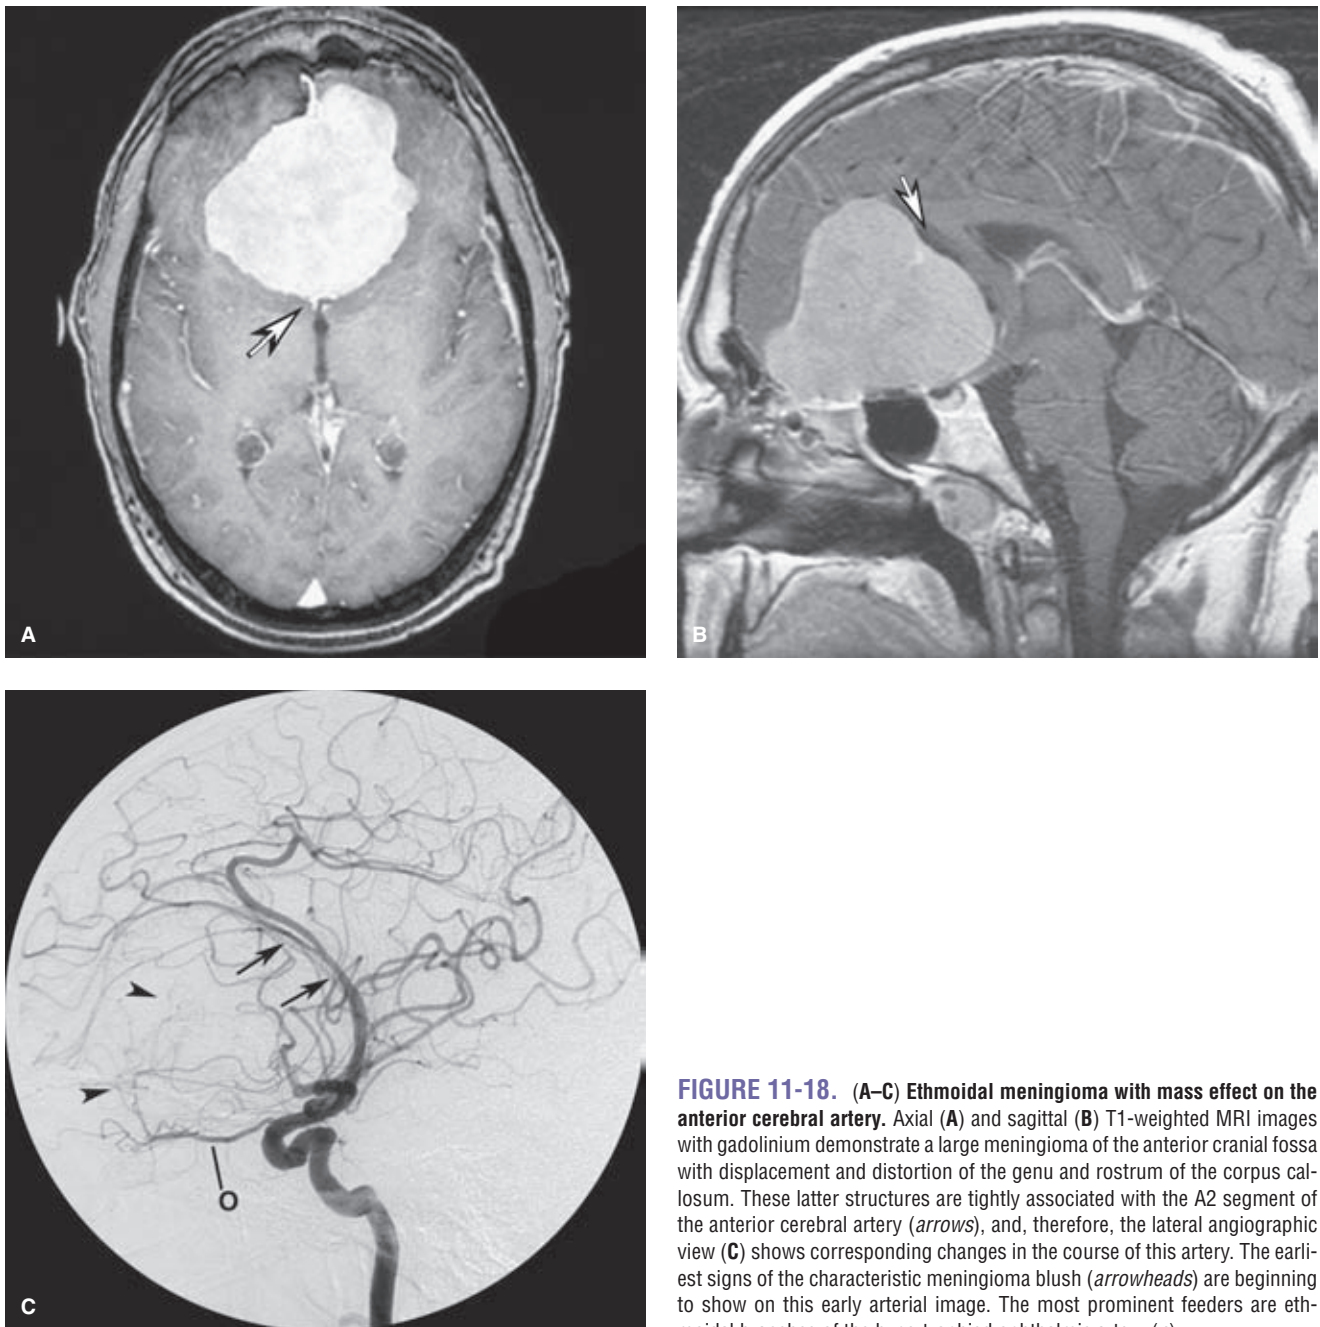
(A–C) Ethmoidal meningioma with mass effect on the anterior cerebral artery. Axial (A) and sagittal (B) T1-weighted MRI images with gadolinium demonstrate a large meningioma of the anterior cranial fossa with displacement and distortion of the genu and rostrum of the corpus callosum. These latter structures are tightly associated with the A2 segment of the anterior cerebral artery (arrows), and, therefore, the lateral angiographic view (C) shows corresponding changes in the course of this artery. The earliest signs of the characteristic meningioma blush (arrowheads) are beginning to show on this early arterial image. The most prominent feeders are ethmoidal branches of the hypertrophied ophthalmic artery (o).
